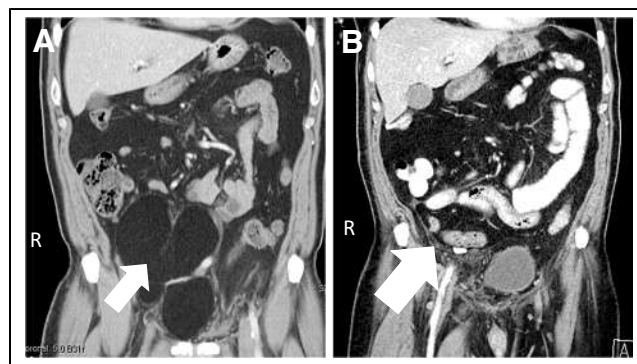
(A) Coronal view of abdomen and pelvis from dedicated diagnostic CT scan showing large lipoma in pelvis. This scan was obtained immediately after MPI study. Arrow shows deviation of urinary bladder before resection. (B) Coronal view from dedicated CT scan after resection of lipoma. Arrow shows where lipoma was before resection.
